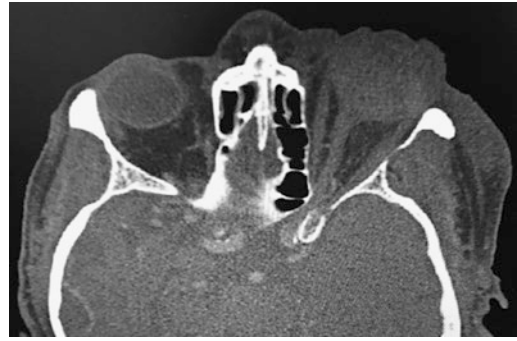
Axial CT of a patient with acute traumatic peribulbar hemorrhage, vitreous hemorrhage and proptosis
